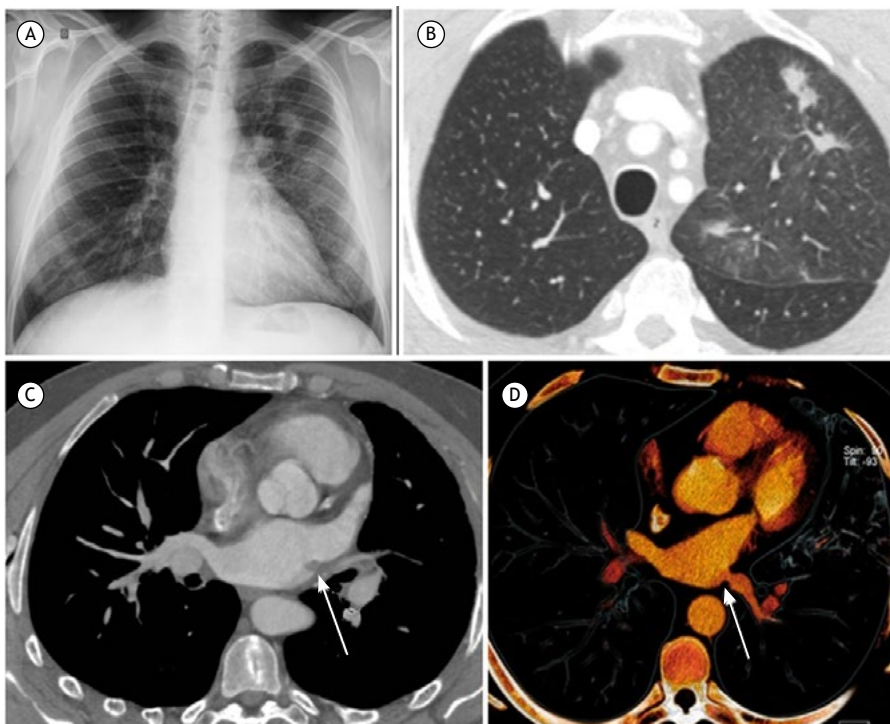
Chest radiography (A) showing pulmonary opacities in the left upper lobe. Axial chest computed tomography (B) demonstrating consolidations, some of which were nodular, ground-glass opacities, and interlobular septal thickening in the left upper lobe, compatible with pulmonary congestion. Axial images acquired at the level of the left atrium showing tapering and filling defects in the pulmonary vein of the left upper lobe (C) (arrow) and stenosis of the ostium of the left inferior pulmonary vein (D) (arrow).
